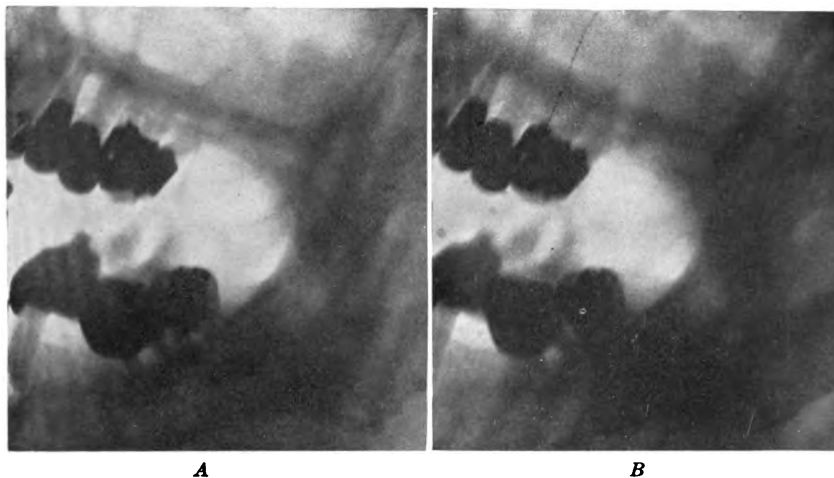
Stereoscopic radiograph of the upper and lower jaws.
